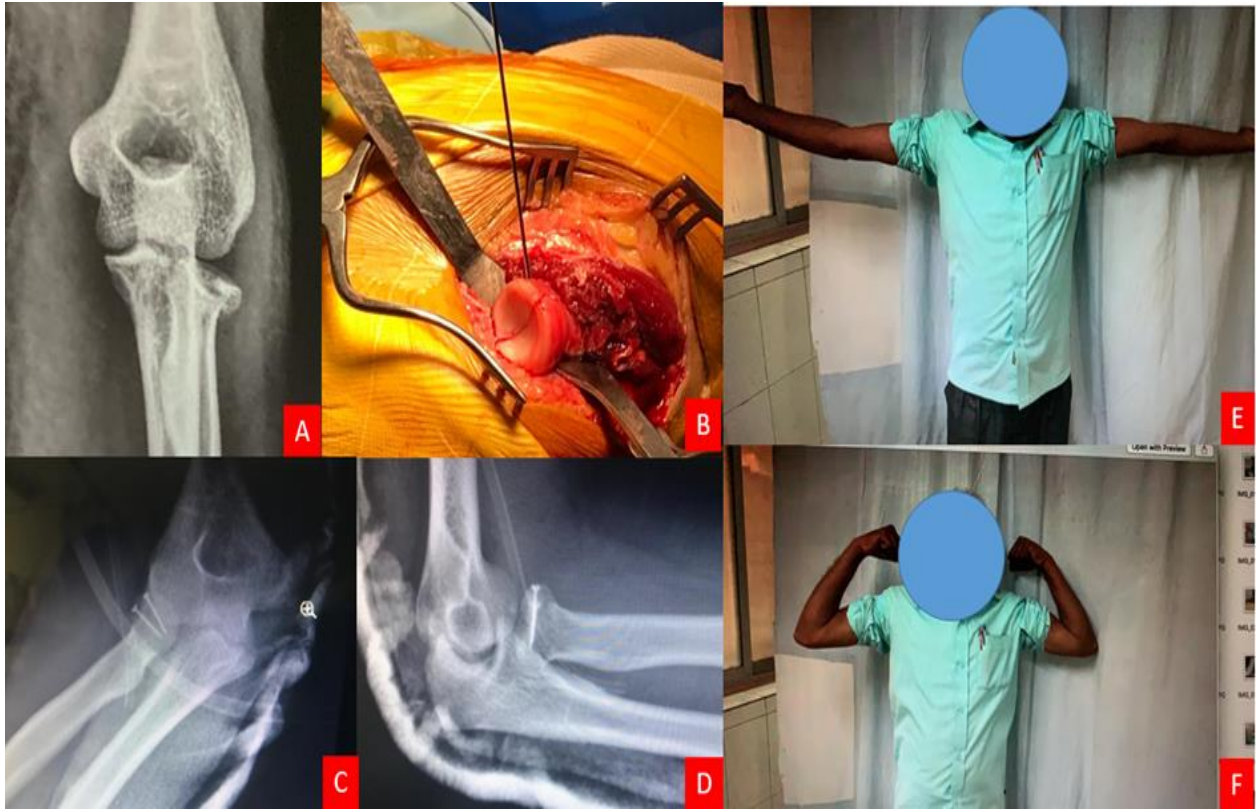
A) Pre-operative X-ray showing Mason's type II radial head fracture. B) Intra-operative image showing fracture reduction held with 1 mm K-wire. C & D) Post-operative X-ray demonstrating ORIF done with screw fixation. E & F) Clinical photos of the patient demonstrating good functional outcome.
